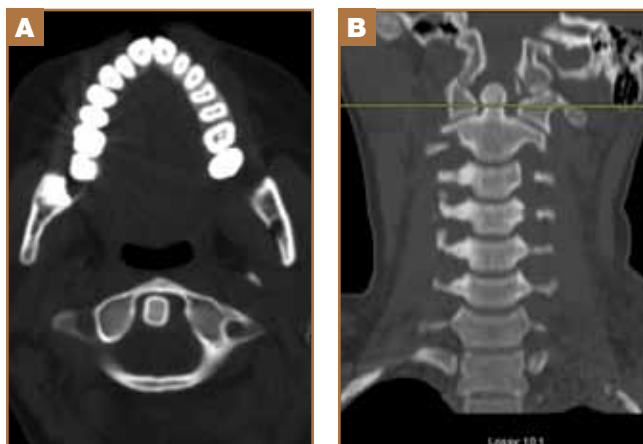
Imaging findings at 1-month follow-up. (A) Axial CT scan showing residual C1/C2 subluxation. (B) Coronal CT reconstruction showing residual C1/C2 subluxation and bone fragment inferomedial to the left occipital condyle.
